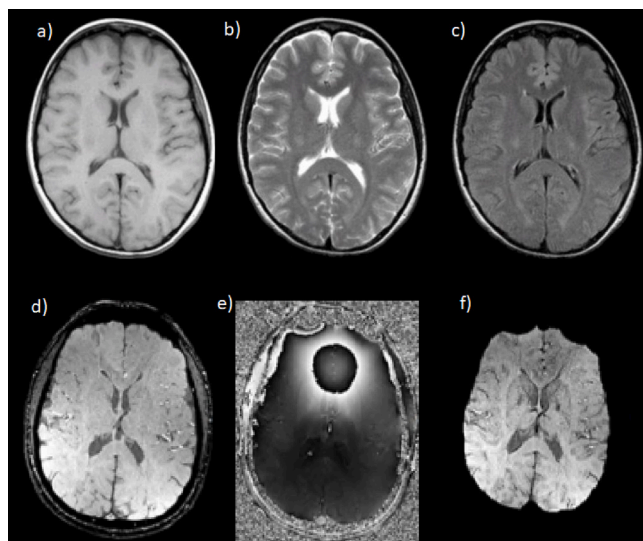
Transverse brain plane. Sequences in first row (Preston, 2016): T1 W (a), T2 W (b), FLAIR (c); in second row (Liu et al., 2017) Magnitude (d), Phase (e), SWI (f).
